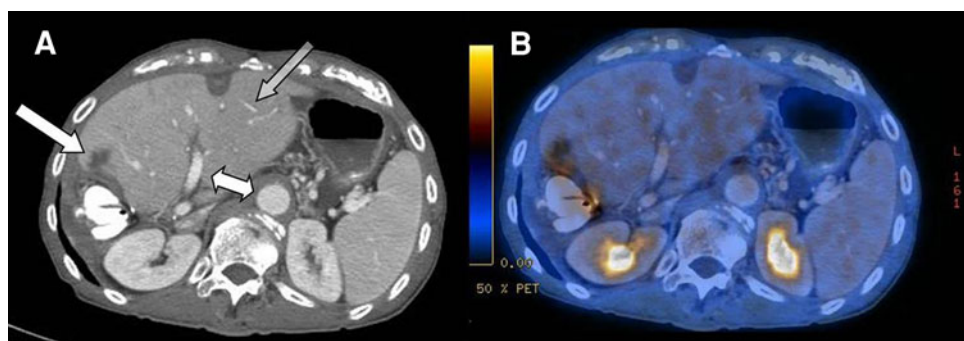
The image quality of the divided contrast protocol in ce-CT (A) and ce-PET/CT (B). The aorta and portal vein (white double-arrow) as well as liver parenchyma and small
